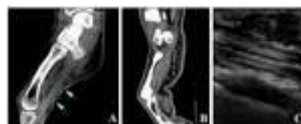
CBCT (A), MSCT (B) and US (C) images of patients with Dupuytren's contracture
